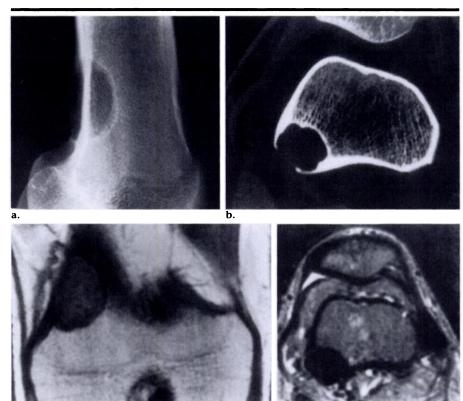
Nonossifying fibroma. (a) Lateral radiograph of the knee shows a 3.5-cm-long lesion involving the posterior femur. The lesion is well circumscribed and has a sclerotic margin. (b) Axial CT image. The lesion has breached the cortex. This is not an unusual finding and should not raise the suspicion of malignancy. (c) Coronal T1-weighted MR image (SE 500/30). (d) Axial T2-weighted MR image (SE 2,000/80). As would be expected for a bland fibrous lesion, this nonossifying fibroma has low signal intensity on both T1- and T2-weighted images. The cortical destruction seen on the CT scan is not evident on the MR images.
